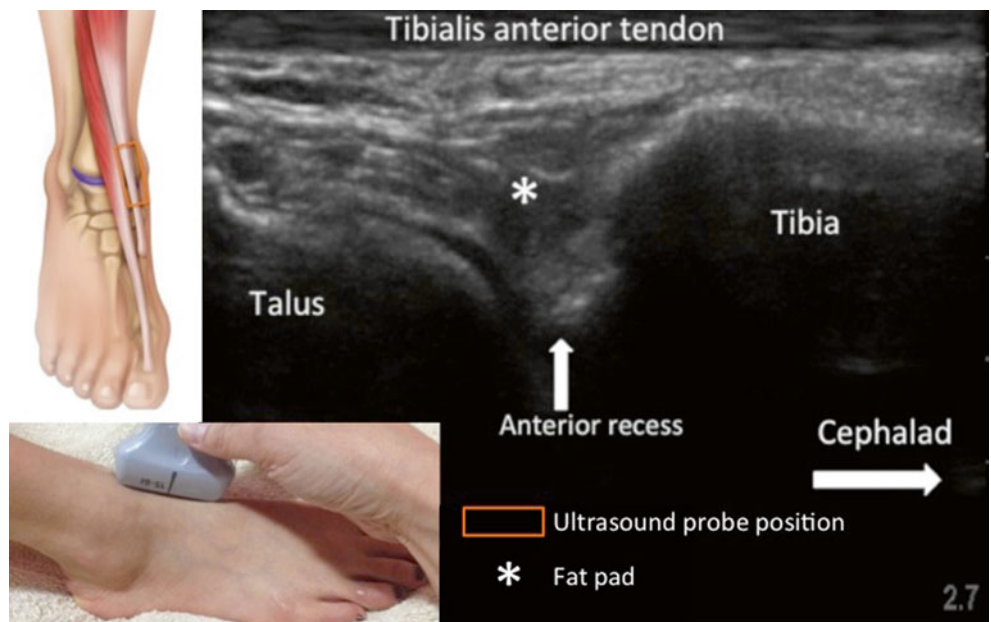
Sonogram of the anterior aspect of tibiotalar joint. The inserts on the left side show the position of the ultrasound probe (*orange rectangle*) (Reproduced with permission from Philip Peng Educational Series)
